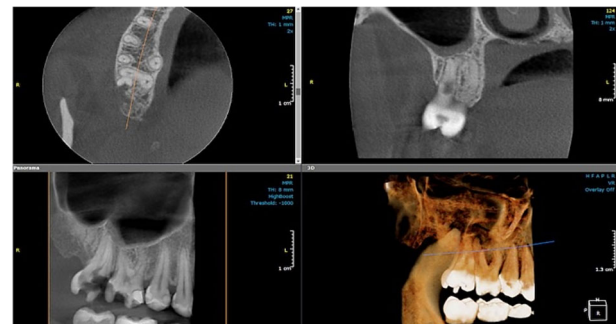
Initial CBCT scans showing the lateral extension of the resorption; the penetration of the lesion into the root canal and the extension under the alveolar crest.
